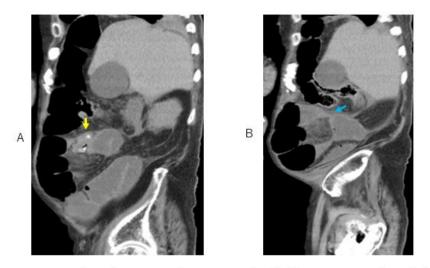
Two days later, swollen appendix (yellow arrow, A) and the occlusive site (blue arrow, B) adjacent with appendix are depicted on sagittal CT. Note mesenteric edema below appendix and occlusive site.
